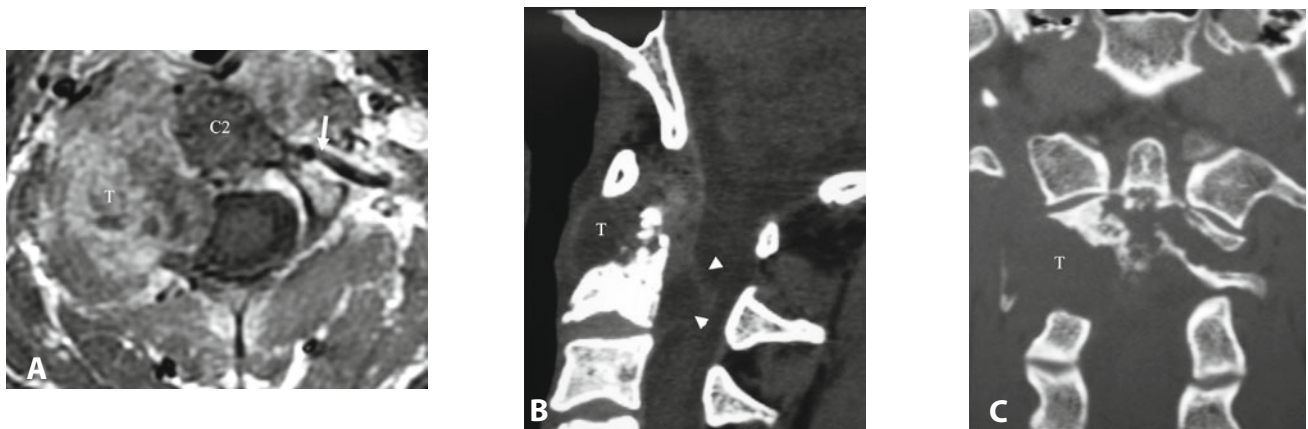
Chordoma. A–B. preoperative axial and sagittal MRI. C–D. Postoperative CT scan. Notice in B the extent of bone resection on the odontoid and up to the contralateral C1–C2 joint. T: tumor.
